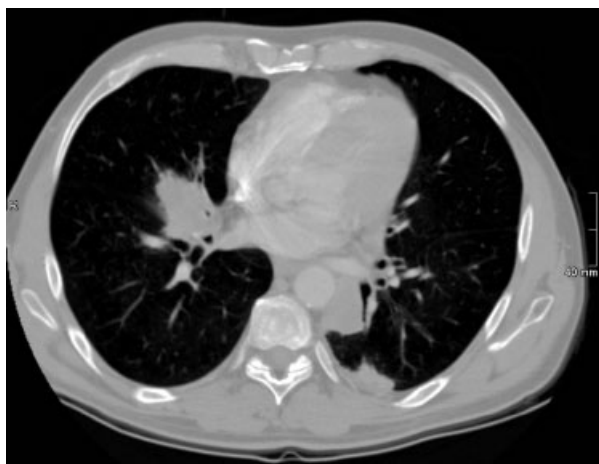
CT scan: Nocardiosis of the lung.
